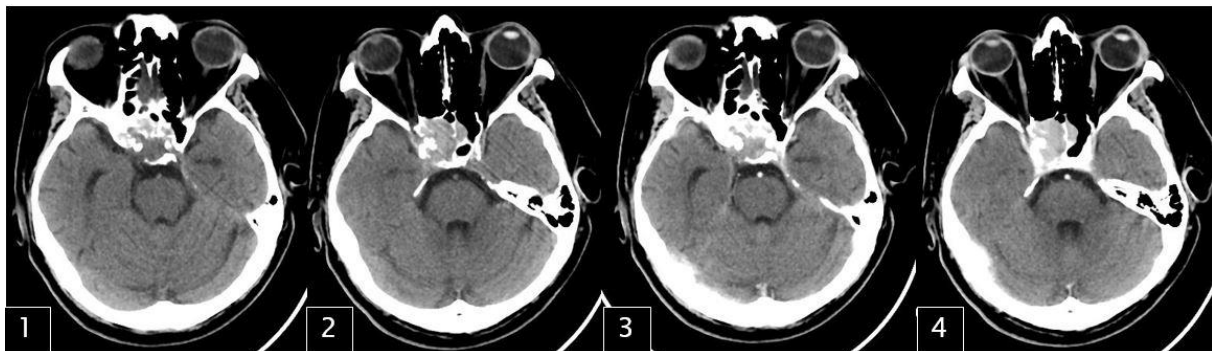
Admission CT brain of Patient 2 [1][2] Plain and [3][4] Contrast enhanced axial sections suggesting Iso to Hyperdense lesion in sellar region with sphenoid extension
